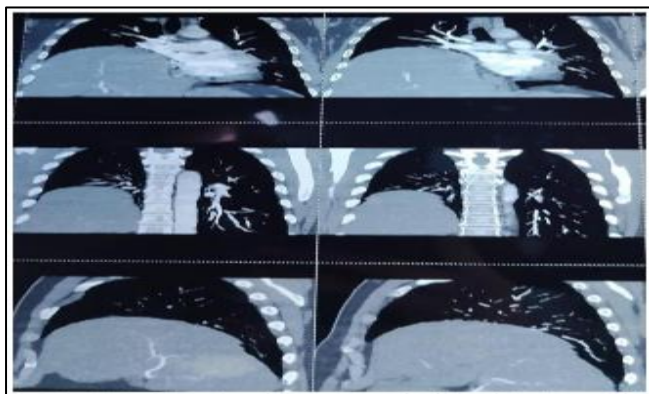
The HRCT of the Patient shows an Elevated Right Hemi-Diaphragm with an Upward Displacement of the Liver, Indicative of Eventration.
